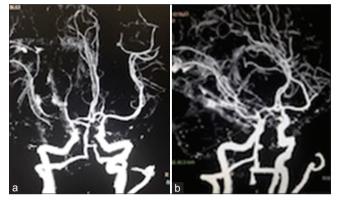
A computed tomography angiography was showing the cut and spasm area of the right middle cerebral arteries (M1 and M2 segments) (a) and cerebral hemorrhage along the arrow's trajectory (b)
